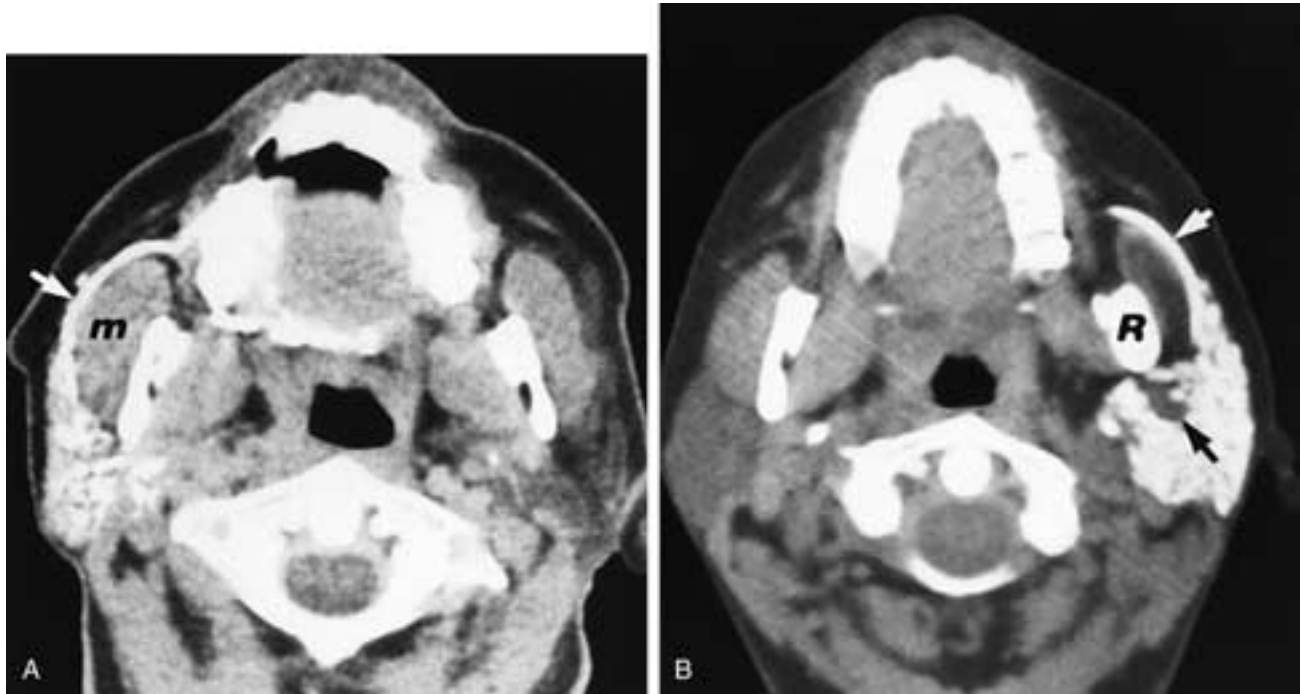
Axial CT scans (A, B) of a normal CT-sialogram of the parotid gland on two different patients. Contrast is seen in the gland and in Stensen's duct (*arrow*) as the duct bends around the masseter muscle (*m*). The location of the posterior facial vein and the external carotid artery can be identified (*black arrow*). Ramus of mandible (*R*).
